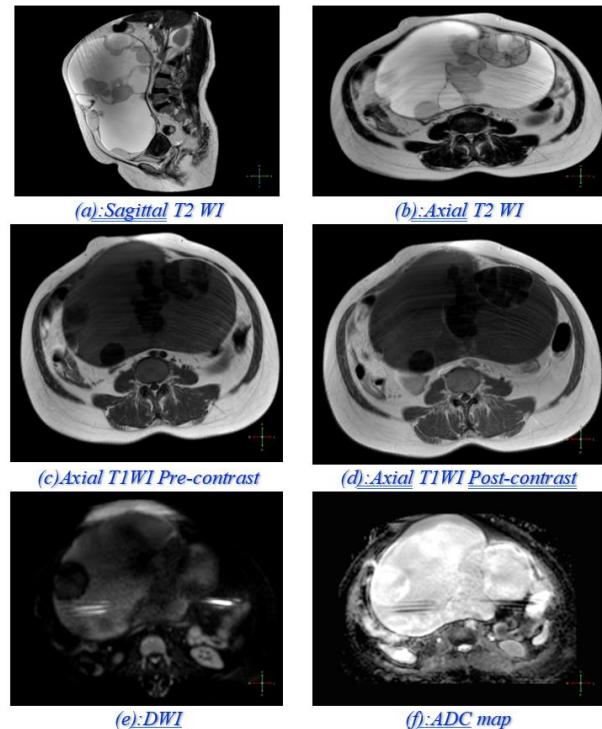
Conventional MRI.
